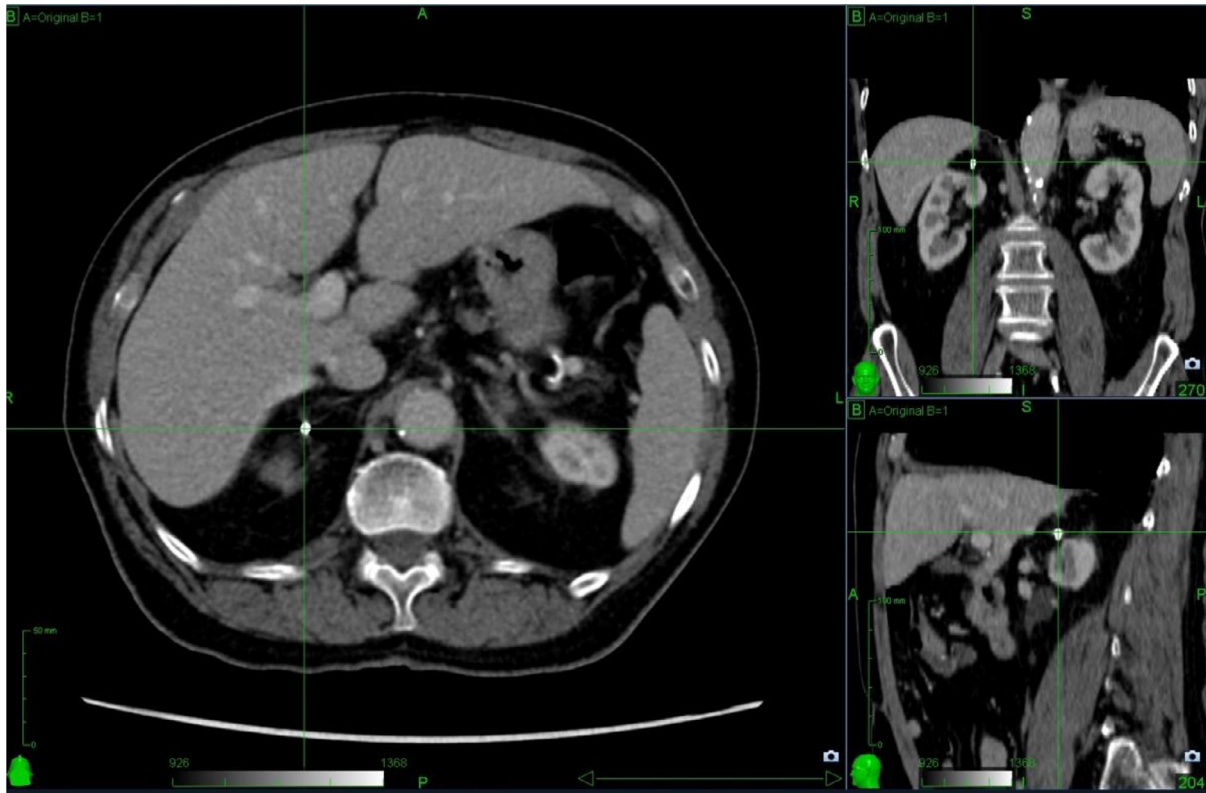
Axial, sagittal, and coronal CT image of treated right adrenal metastasis, 7 years postradiosurgery, May 2019. CT, computed tomography.
